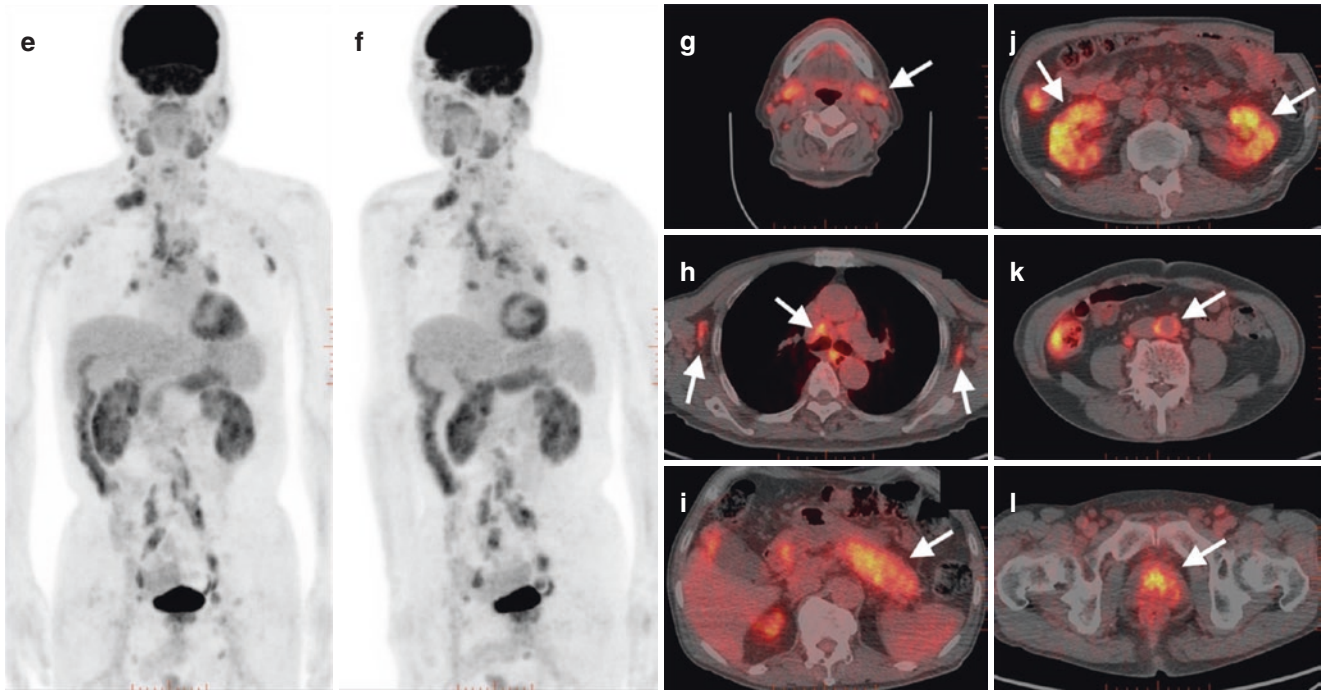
Case 2 ¹⁸F-FDG PET/CT
